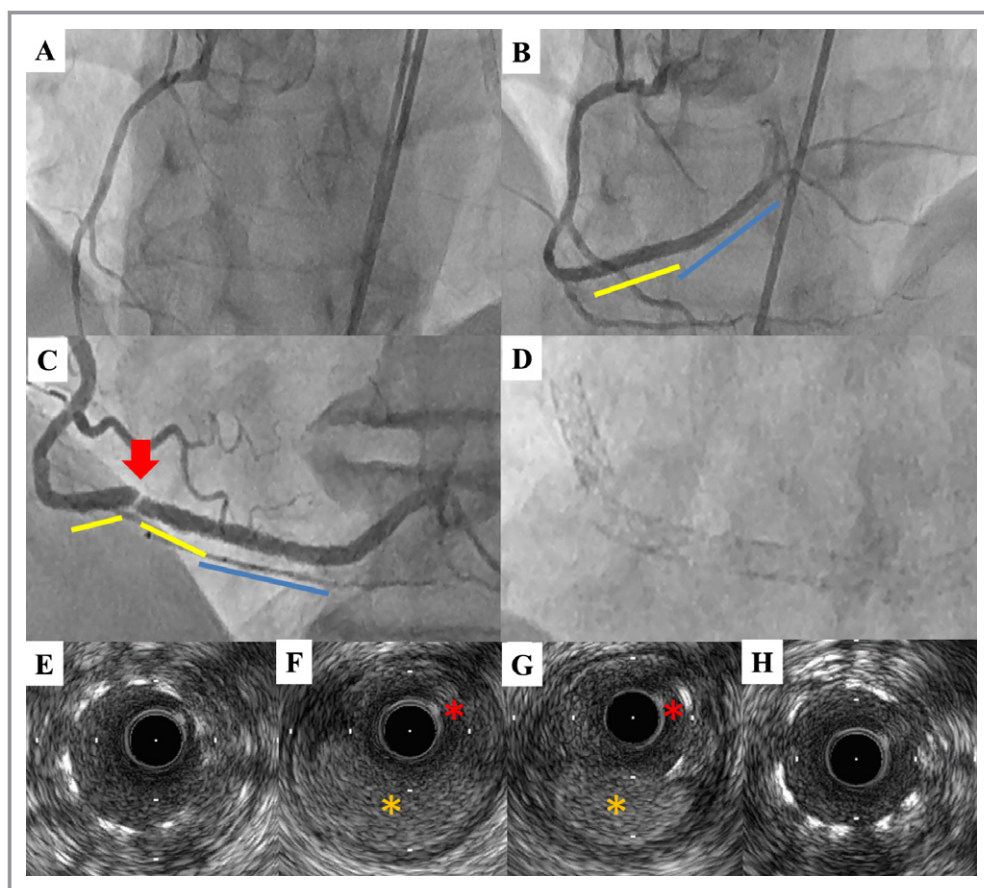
Representative case of stent fracture. A, Coronary angiography shows a lesion with chronic total occlusion at distal right coronary artery. B, Final results after implantation of 2 biolimus-eluting stents with overlap (2.5×24 mm [yellow line] and 2.5×28 mm [blue line]). C, At 6 months after implantation, angiography shows 99% stenosis with stent fracture (red arrow) at the mid-portion of implanted stent. D, Magnified image without contrast at follow-up. E through H, The sequence of 4 intravascular ultrasound (IVUS) image slices with 0.5-mm intervals at minimal lumen diameter from proximal (E) to distal site (H). IVUS shows the complete absence of stent strut (F) and that stent fracture is occurred at the borderline between true arterial lumen (yellow asterisk) and subintimal space (red asterisk) (F and G).
